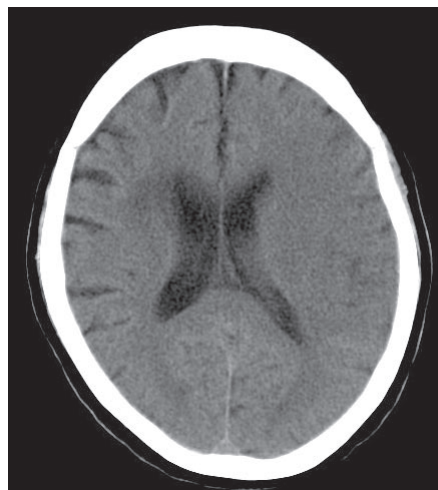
Non-contrast axial CT brain.
